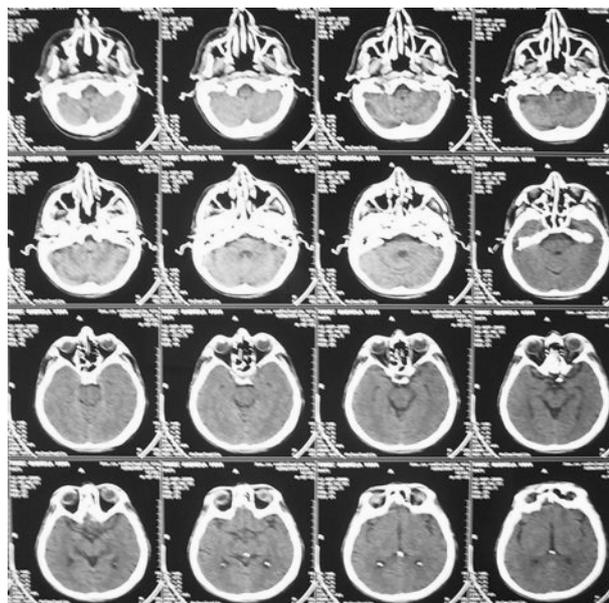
Paranasal sinuses CT
